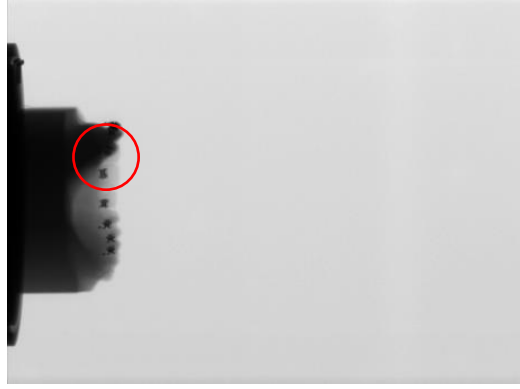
A slice from CBCT projection data of jaw. Bone and metal intensities are particularly close to each other in the marked region above.
